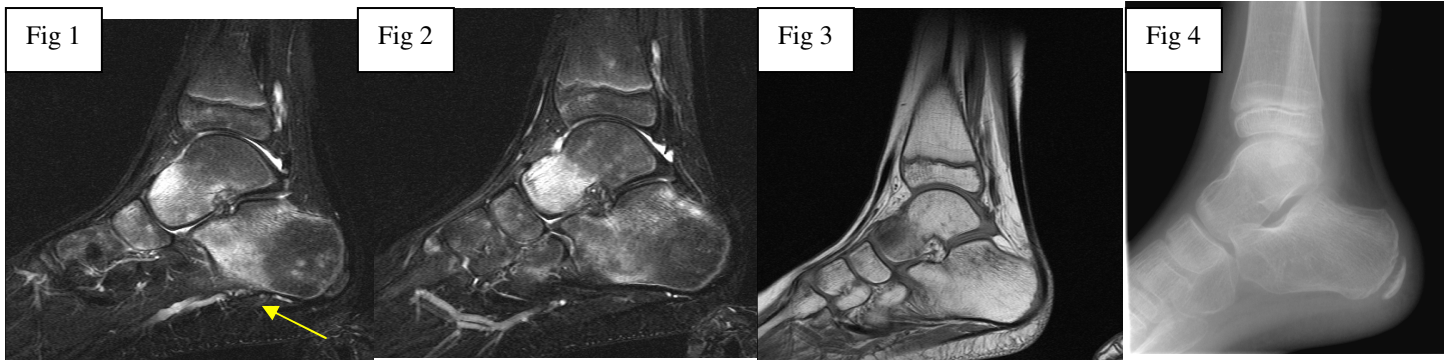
Sagittal STIR images showing bright marrow edema in multiple bones, especially talus and calcaneus. Fig.3: Sagittal T1W showing dark edema in talus. Fig 4: Lateral x-ray showing no definite fractures.
